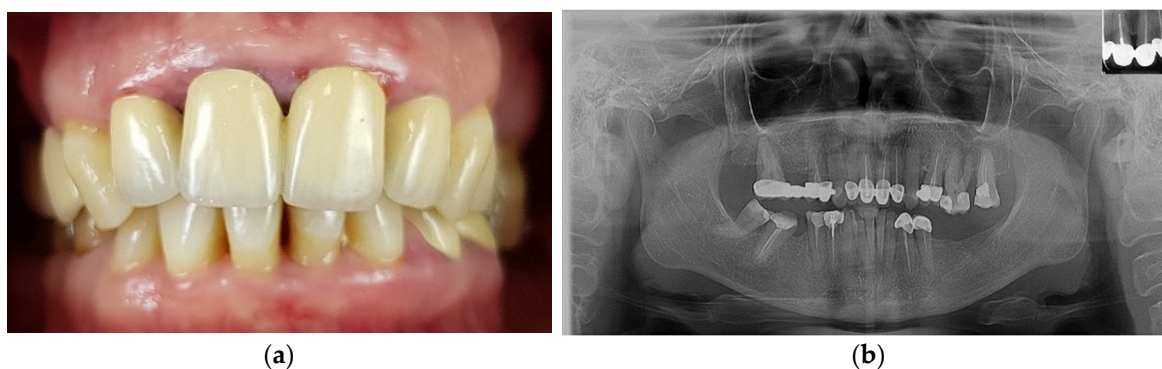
Initial situation of the patient: (a) Unaesthetic metal-ceramic crowns with chronic inflammation of the gingival margins and oblique interincisal line; (b) Initial panoramic X-ray.
